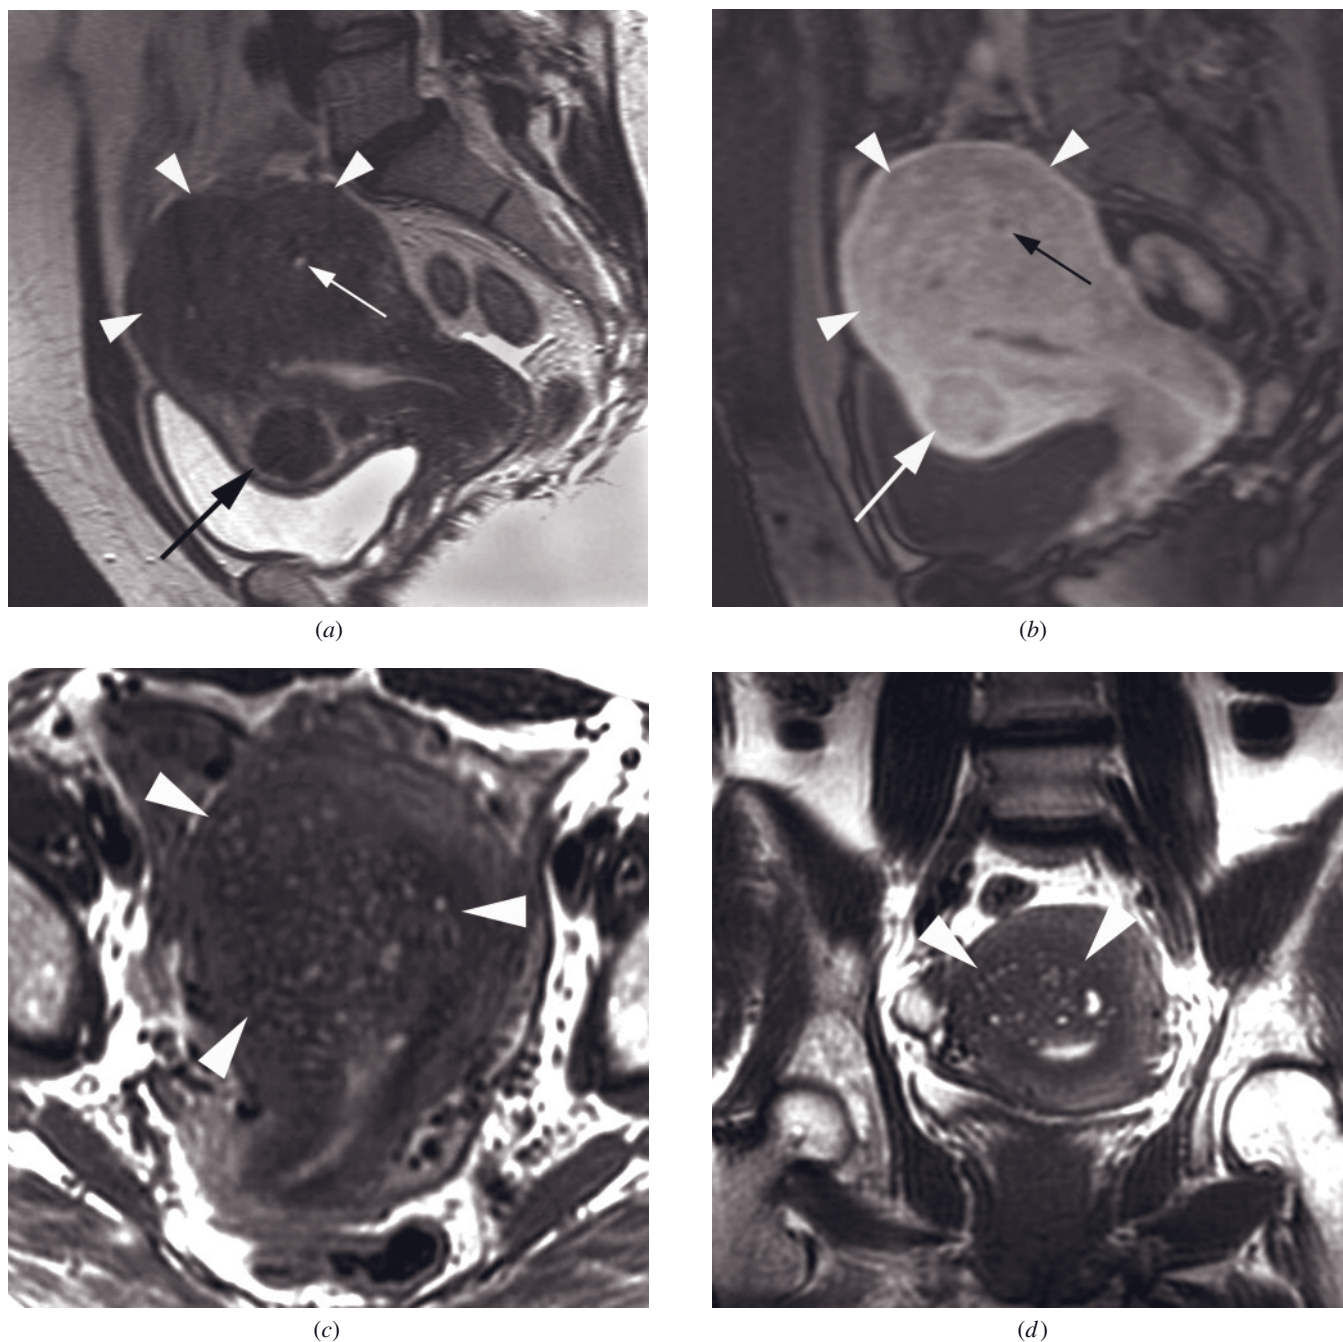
Focal adenomyosis and leiomyoma. Sagittal T2-weighted ETSE (*a*) and fat-suppressed T1-weighted gradient-echo (*b*) images show a hypointense masslike region in the uterine fundus (arrowheads) that is continuous with the junctional zone. The mass contains punctate foci that are hyperintense on T2-weighted images (white arrow, *a*) and hypointense on gadolinium-enhanced images (black arrow, *b*). Also note that the mass effect on the endometrium is minimal given the size of the lesion, even less than that of the smaller leiomyoma (black arrow, *a*; white arrow, *b*). Adenomyomas are generally oblong rather than round and do not have the hyperintense rim on T2-weighted images that is often seen in leiomyomas (black arrow, *a*). Focal adenomyosis at 3T. Transverse (*c*) and coronal (*d*) T2-weighted ETSE images in another patient show a hypointense masslike region in the posterior uterine wall (arrowheads) that is continuous with the junctional zone and contains punctate hyperintense foci characteristic of adenomyosis.
